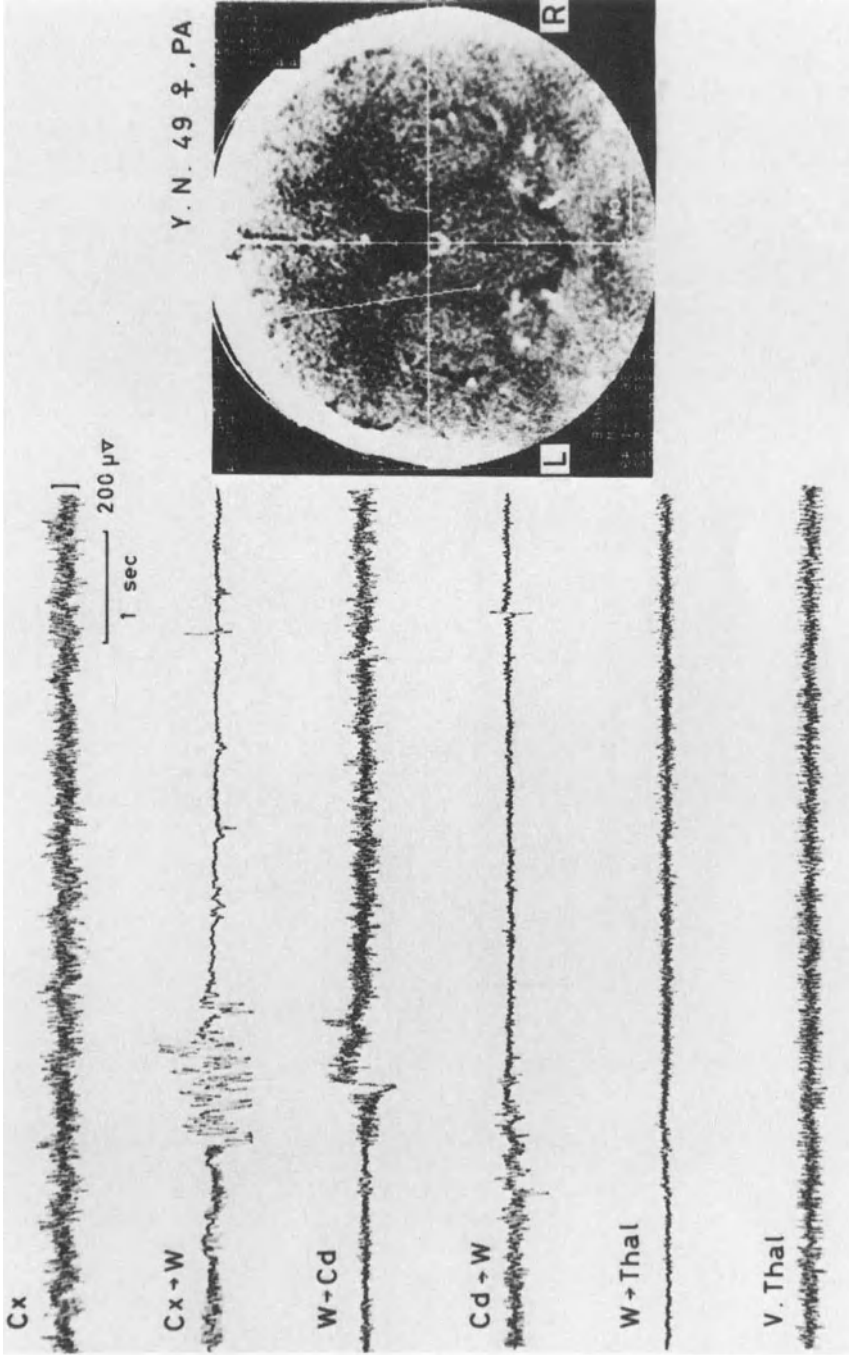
Examples of characteristic electrical activities in the cortical and deep subcortical structures are shown along the trajectory toward the tentative target point. The expected direction of the trajectory is drawn (*white line*) on the stereotactic CT image on the right.
